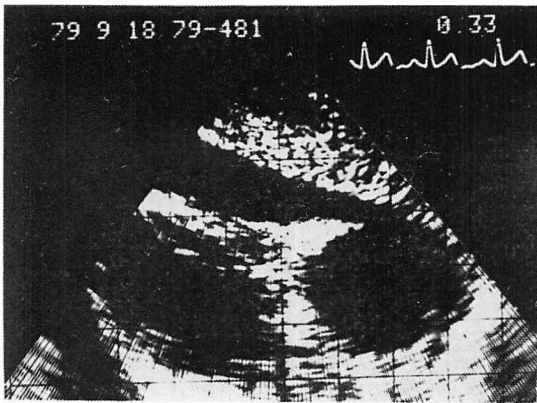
Two-dimensional echocardiogram (sub-costal view) showing massive pericardial effusion.
